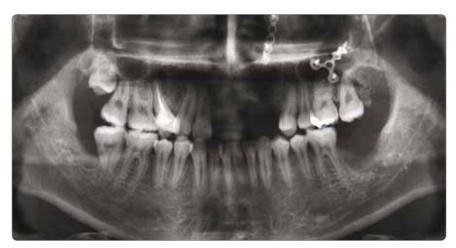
Pre-op radiography
